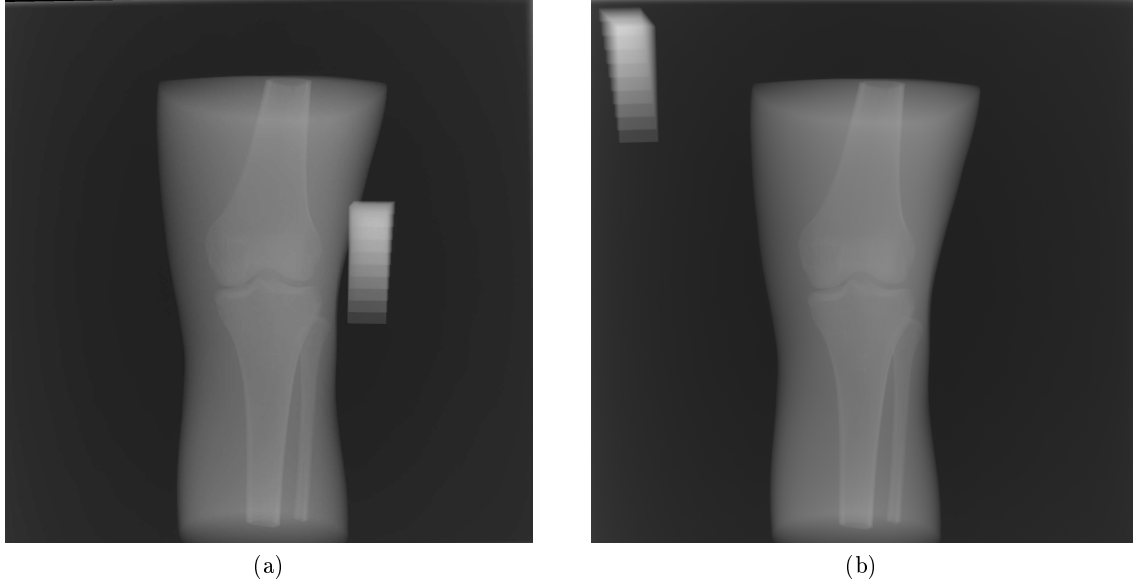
X-rays of the knee with the wedge in the a) central position and b) top left corner.
